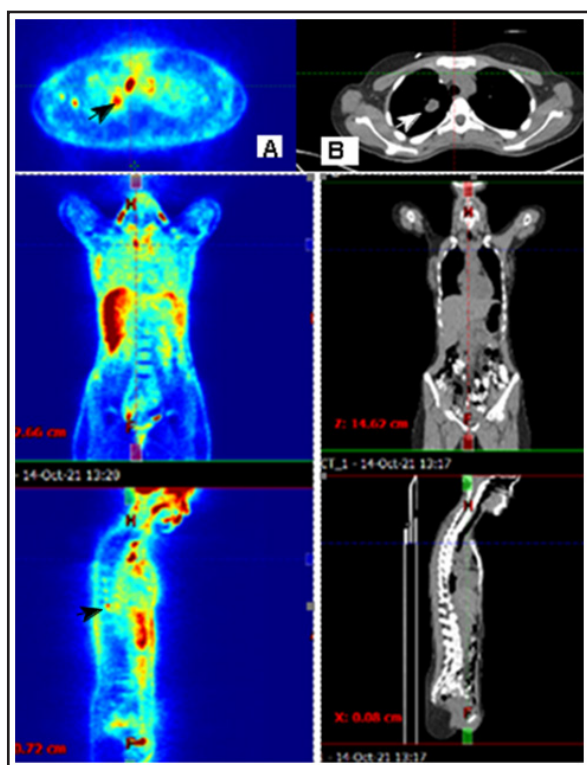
FDG PET/CT October 2021 A/ Right lung- Slightly increased nodular lesion with a diameter of 25.5 mm x 18 mm with reduced metabolic activity SUVmax 3.41; ventral in the third lung segment nodular lesion with a diameter of 10.5 mm x 6.2 mm
